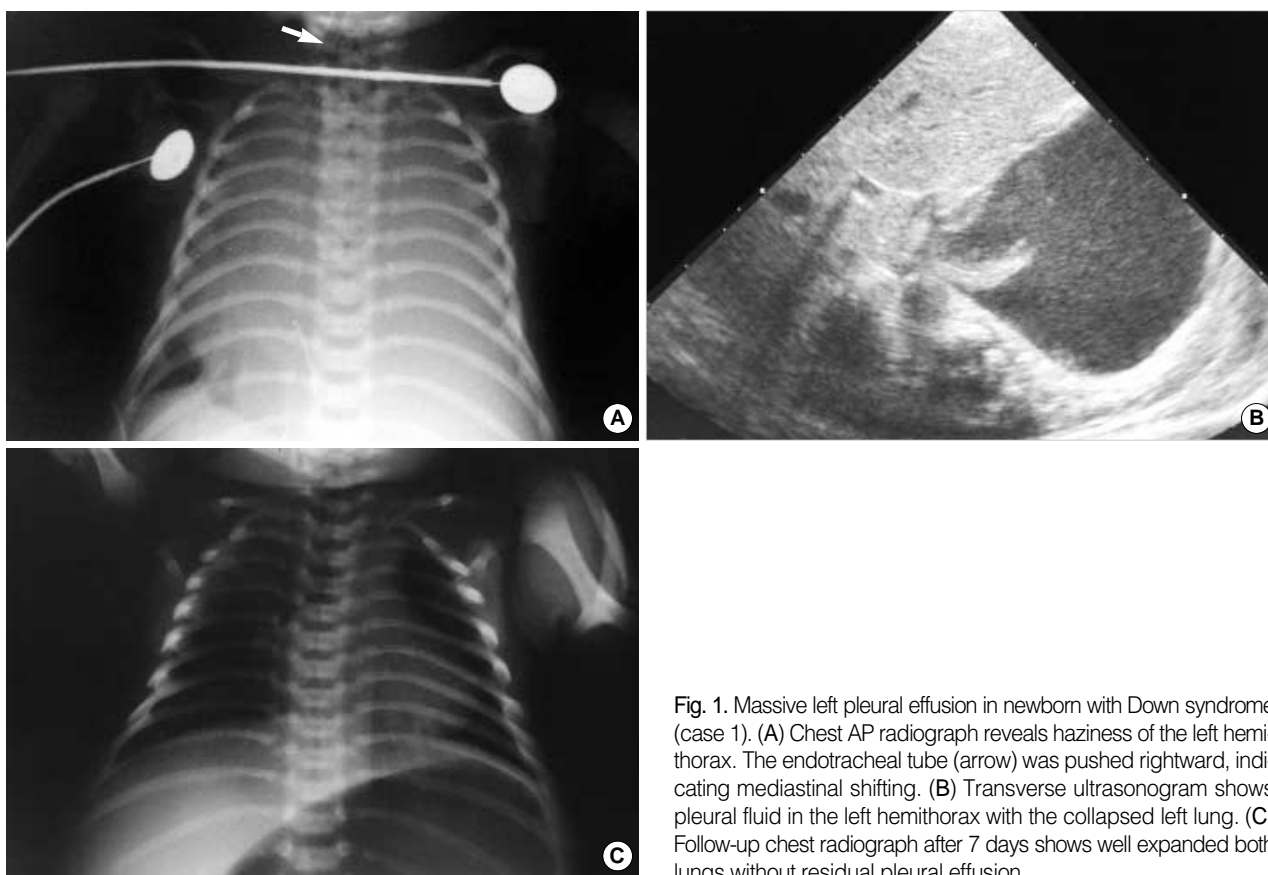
Massive left pleural effusion in newborn with Down syndrome (case 1). (A) Chest AP radiograph reveals haziness of the left hemithorax. The endotracheal tube (arrow) was pushed rightward, indicating mediastinal shifting. (B) Transverse ultrasonogram shows pleural fluid in the left hemithorax with the collapsed left lung. (C) Follow-up chest radiograph after 7 days shows well expanded both lungs without residual pleural effusion.
